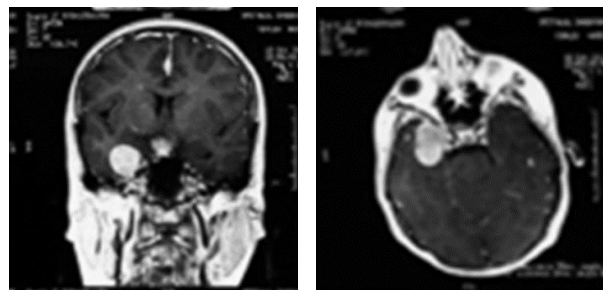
Cerebral gadolinium-enhanced MRI scan showing an expansive process of the sellar and parasellar region with temporal lobe extension.
